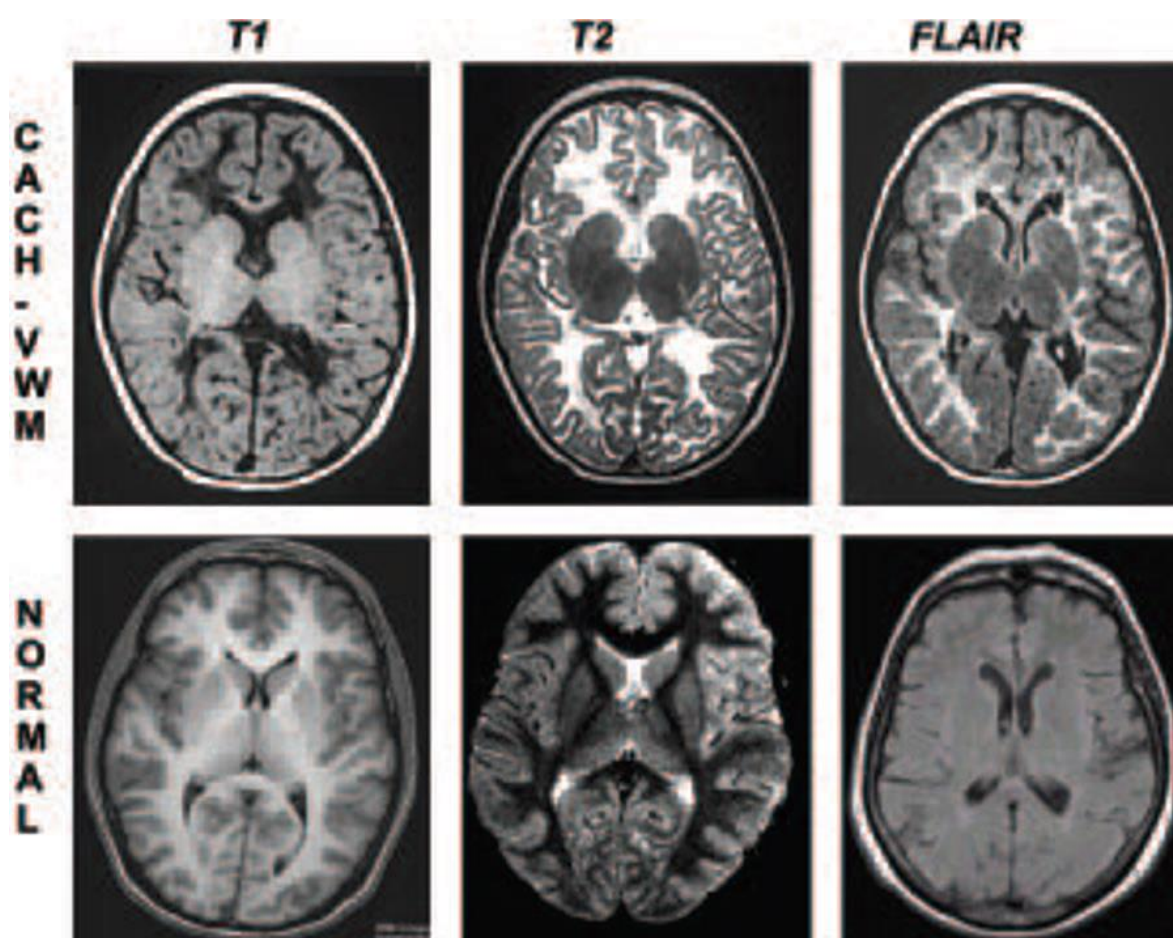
MRI aspects of the white matter from a CACH/ VWM patient of 5 years old in comparison to an age-matched healthy control. White matter presents a signal closed to CSF on T1- and T2- weighted images. Cavitating zones appear in the frontal white matter on FLAIR sequences (Labauge et al., 2007).
